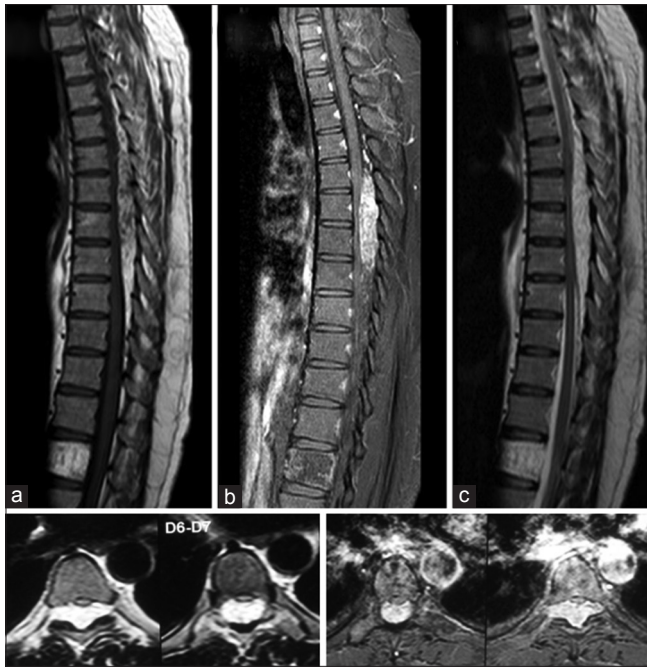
Sagittal and axial cuts of magnetic resonance imaging showing large, extradural, contrast-enhancing lesion extending from D5 to D8 with hemangioma in L1 vertebral body. (a) T1-weighted images. (b) Fat-suppressed postcontrast image. (c) T2-weighted images
